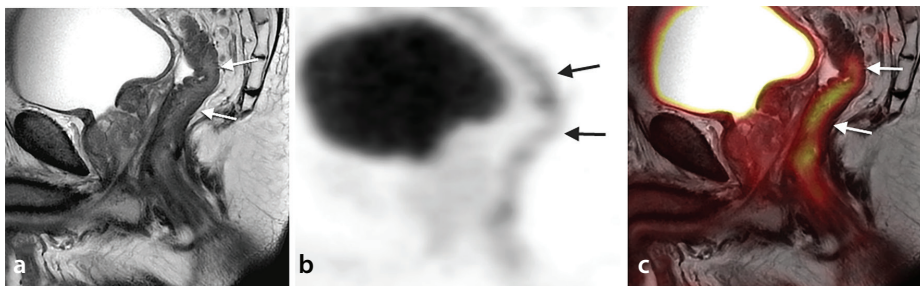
Ulcerative colitis. In the patient who underwent rectal excision, the sagittal T2-weighted magnetic resonance image (MRI) (a) shows subtle wall thickening and loss of haustration of the colon segment (arrows) that is pulled into the pelvis for coloanal anastomosis. The sagittal positron emission tomography (PET) (b) and sagittal fused PET/MRI (c) demonstrate diffuse, linear fluorodeoxyglucose uptake in the affected bowel segment (arrows).
